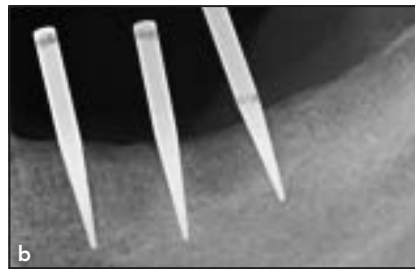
(a) The parallel pins inserted from the cone-shaped portion to ensure the correct initial axis of preparation; (b) radiograph; (c) the cortical crestal view after the first bone surgical perforation using the IM1 insert.
